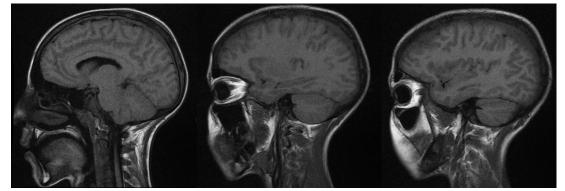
Image showing sections of the brain MRI, T1 sequence, in the sagittal plane showing the thickening of the meninges in ypo-signal
